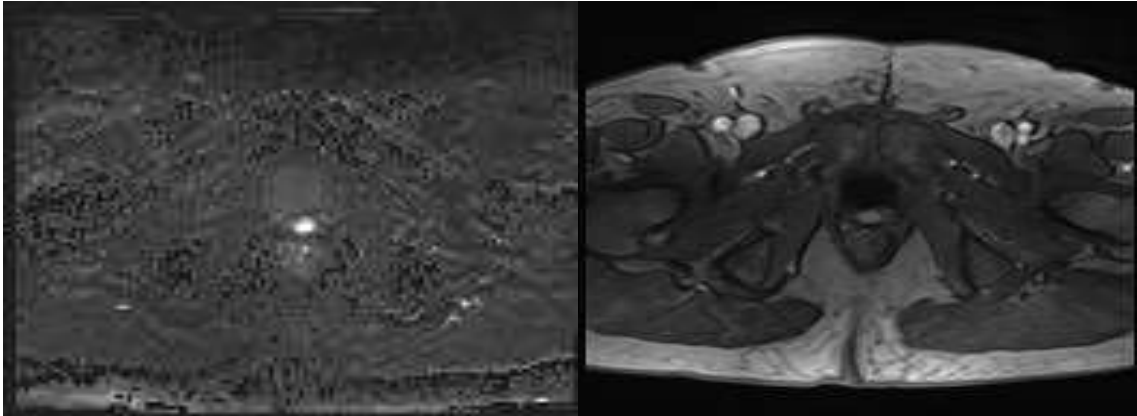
Intraprostatic recurrent disease identified in patient BCR020; (A) PSMA avid recurrent intraprostatic disease in the right peripheral zone on MRAC PET (B) Area of enhancement on dynamic MRI series correlating with PET (C) disease visible on SOC contrast CT correlating with PSMA PET findings (white arrows).
